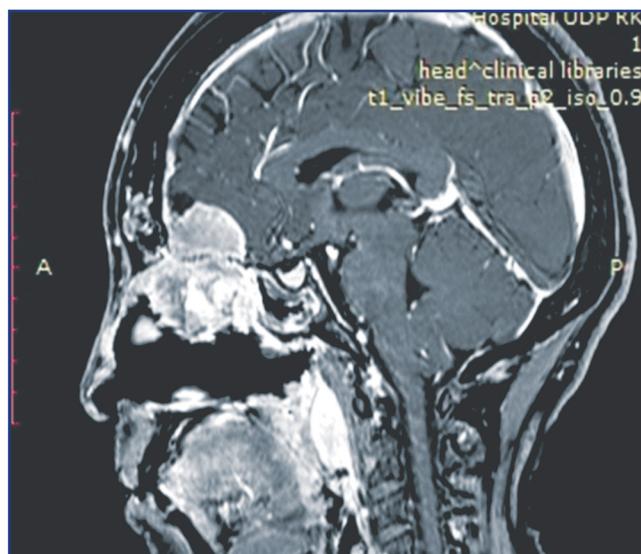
T2-weighted image in a sagittal projection demonstrates the presence of formation of the anterior cranial fossa with invasion to the right half of ethmoid bone cells and the orbit
